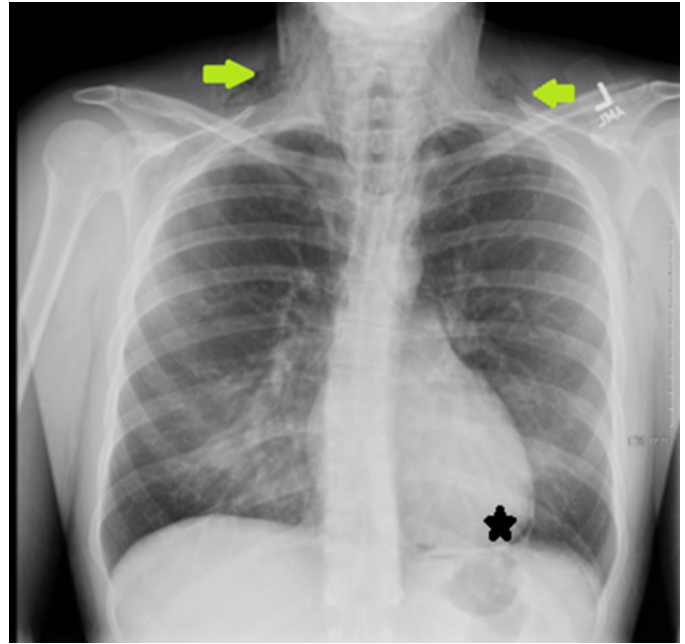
Chest X-ray showing subcutaneous emphysema (arrows) and pneumopericardium (star).
